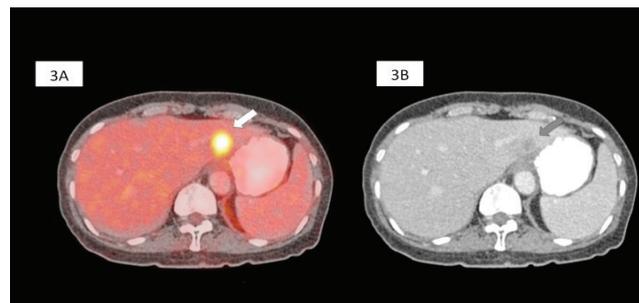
A 62-year old lady with Stage IV NSCLC had a PET/CT scan done for re-staging (A): There was FDG hypermetabolism detected at segment VIII of the liver, SUV_{max} 10.4g/mL (white arrow) (B) However, on axial plane whole body CT scan image in soft tissue window (W:250, L:50) at the level of the liver showed a vague hypodense focus (grey arrow) at the corresponding site in keeping with site of metastasis (inconspicuous on CT compared to PET).
